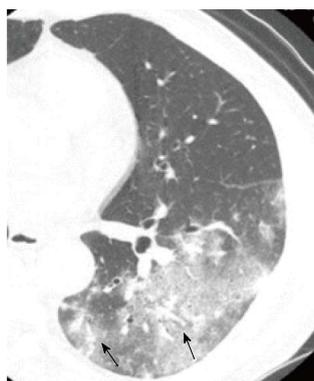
Chlamydomphila pneumoniae* pneumonia showing ground-glass opacity predominant pneumonia in a man in her 60s. Thin-section computed tomography shows patchy ground-glass opacity in the left lower lobe, in which thickened bronchovascular bundles are present (arrows).
